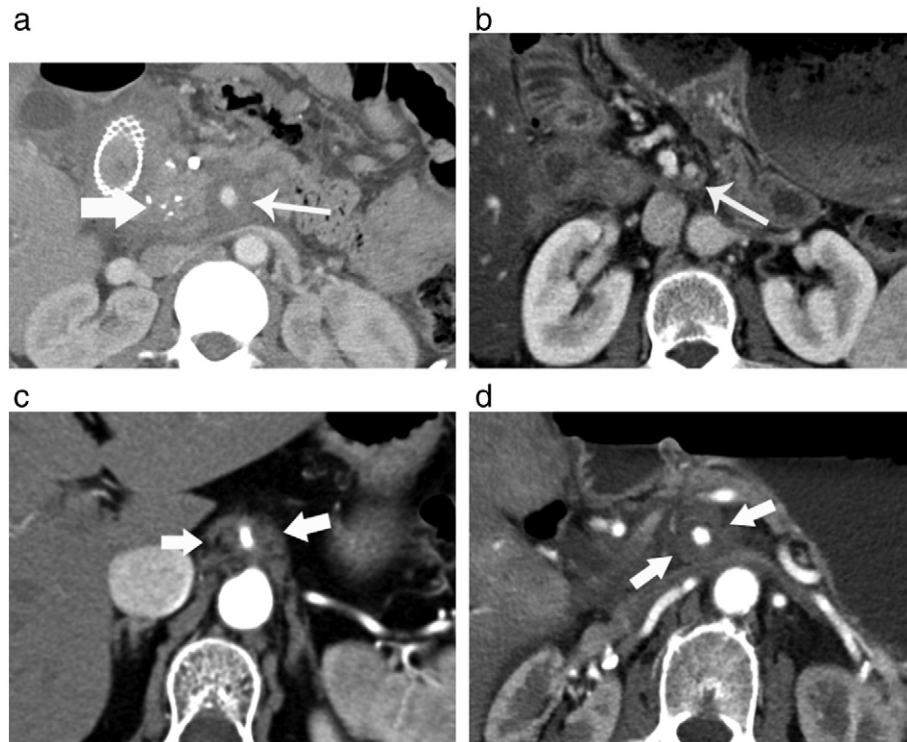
Perivascular metastatic disease from pancreatic adenocarcinoma and its mimickers. (a) A 4-year-old man with chronic calcific alcoholic pancreatitis. Axial contrast-enhanced CT image shows soft tissue thickening around the SMA (thin arrow) representing fibrosis that was stable on multiple follow-up examinations over the course of 3 years. Multiple foci of calcifications are seen in the pancreatic head (thick arrow) due to chronic pancreatitis. Endoscopic ultrasound with fine needle aspiration showed chronic inflammatory changes, and these changes remained stable over multiple follow-ups. (b) A 51-year-old man status post Whipple procedure for pancreatic adenocarcinoma. Axial contrast-enhanced CT image obtained 2 years postsurgery demonstrates small crescent-shaped soft tissue abutting the SMA (arrow) with no interval growth since surgery. This is a common finding after pancreaticoduodenectomy, and recurrence in this area should only be suspected in the presence of an increasing size and attenuation of the adjacent vessels. (c) A 68-year-old woman with vasculitis. Axial contrast-enhanced arterial phase CT image demonstrates soft tissue encasement of the celiac axis (thick arrows). The pancreas was normal in appearance without a mass lesion or ductal dilation. The perivascular soft tissue thickening completely resolved on the 6-month follow-up CT study. (d) A 77-year-old man with pancreatic adenocarcinoma. Axial contrast-enhanced arterial phase CT image demonstrates soft tissue encasement of the SMA (thick arrows) without an obvious mass lesion in the pancreas. Due to high clinical suspicion and elevated CA 19-9, metastatic pancreatic adenocarcinoma was confirmed on exploratory laparotomy sampling of the soft tissue.
